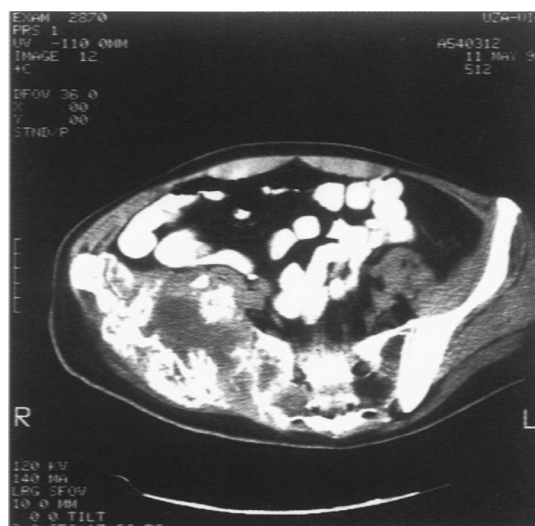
CT image shows the large recurrent tumour with hyperdense and radiolucent areas invading the sacrum 3 months after iliac bone resection and despite intensive chemotherapy
